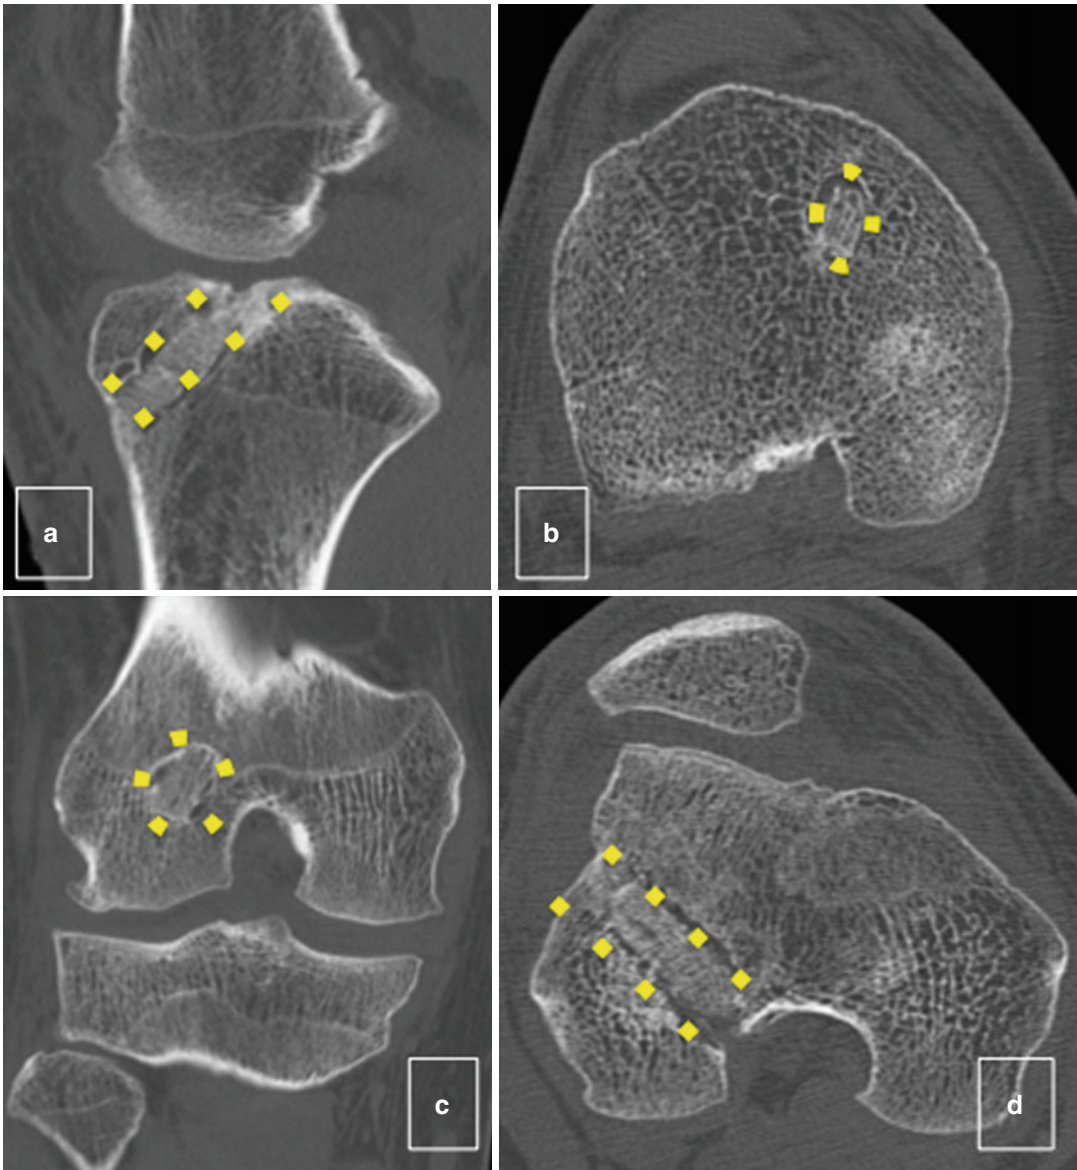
CT scan 4 months after the first of two-stage procedure. Graft is incorporated in the tunnel; (a, b) Tibia, (c, d) femur
